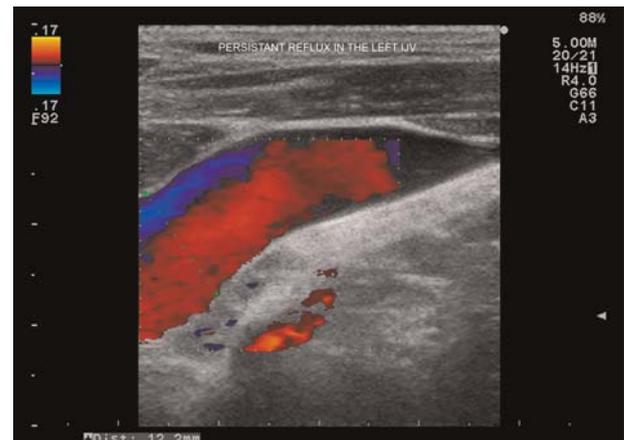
Colour Doppler sonography: persistent reflux in the left IJV – persistent for more than 0.88 seconds
